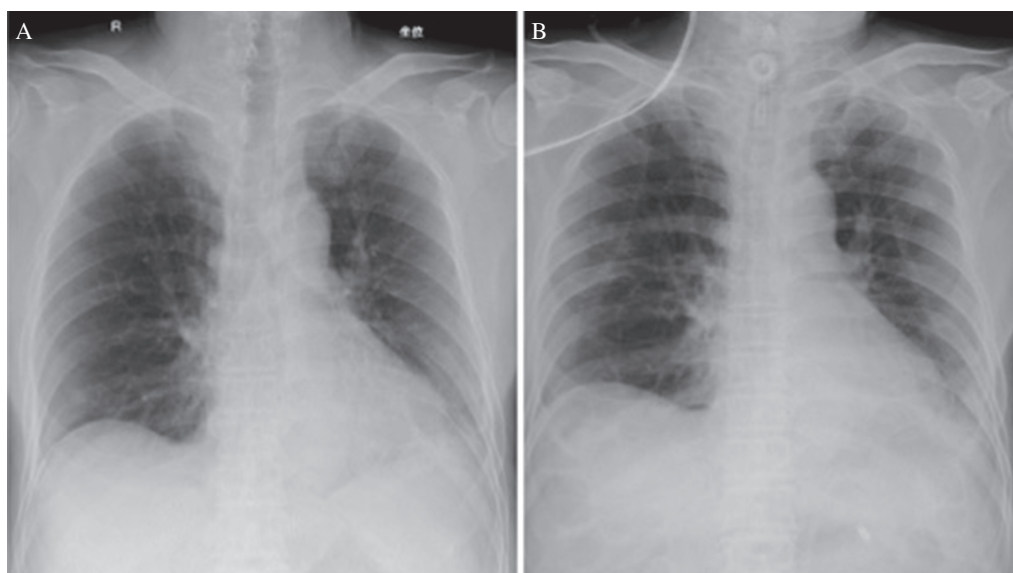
Chest X-ray of postoperative day 0 (A) and day 16 (B) revealed no severe pneumonia and atelectasis.
